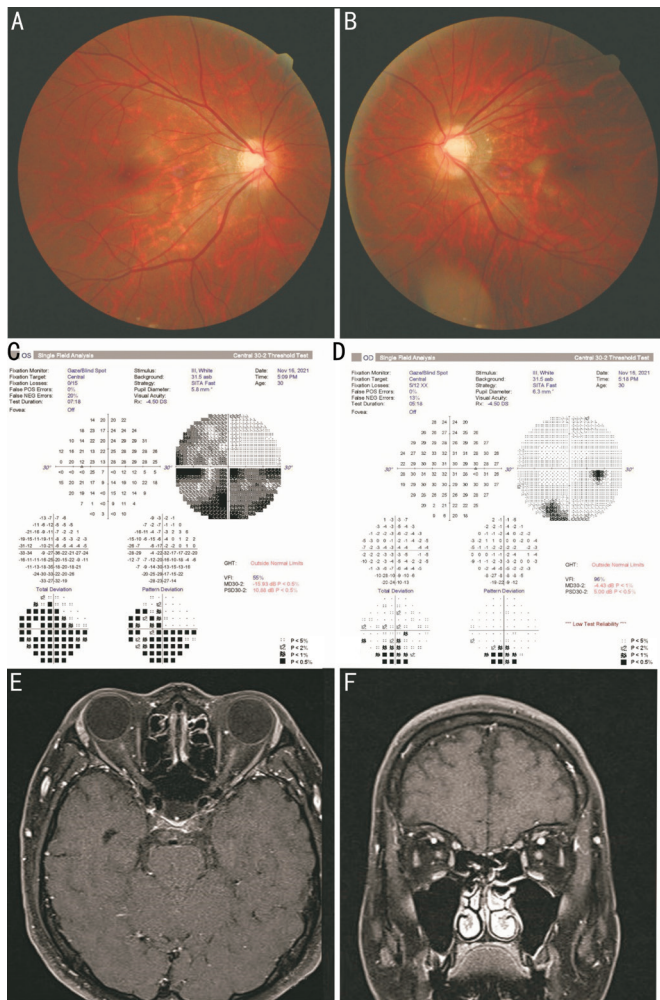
Initial clinical presentation of the patient A, B: Fundus photographs showed no specific findings; C, D: Bilateral visual field defect was observed which was prominent in the left eye; E, F: Bilateral optic nerve enhancement at T1-weighted image in magnetic resonance imaging.
